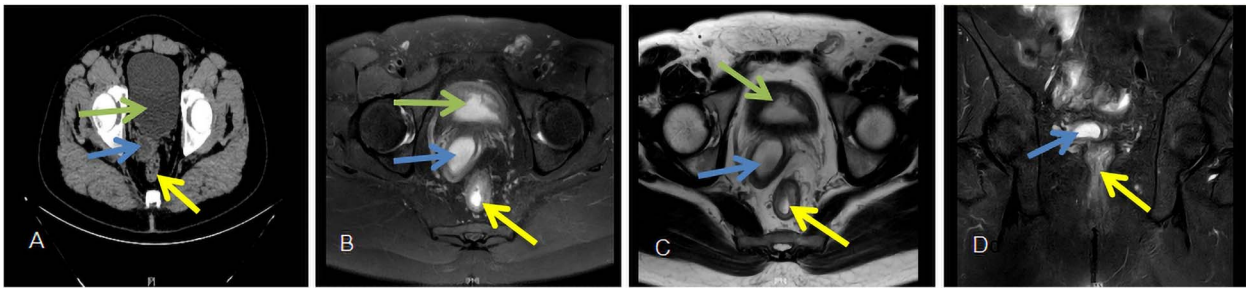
Computed tomography scan image and magnetic resonance imaging results: topmost arrows, bladder; middle arrows, the location of the uterus; bottom arrows, rectum. (A) Patient's pelvic computed tomography scan. (B) T2 sequence image of magnetic resonance imaging. (C) T1 sequence image of magnetic resonance imaging. (D) Coronal image of magnetic resonance (The arrow above, the location of the uterus; the arrow below, rectum).
